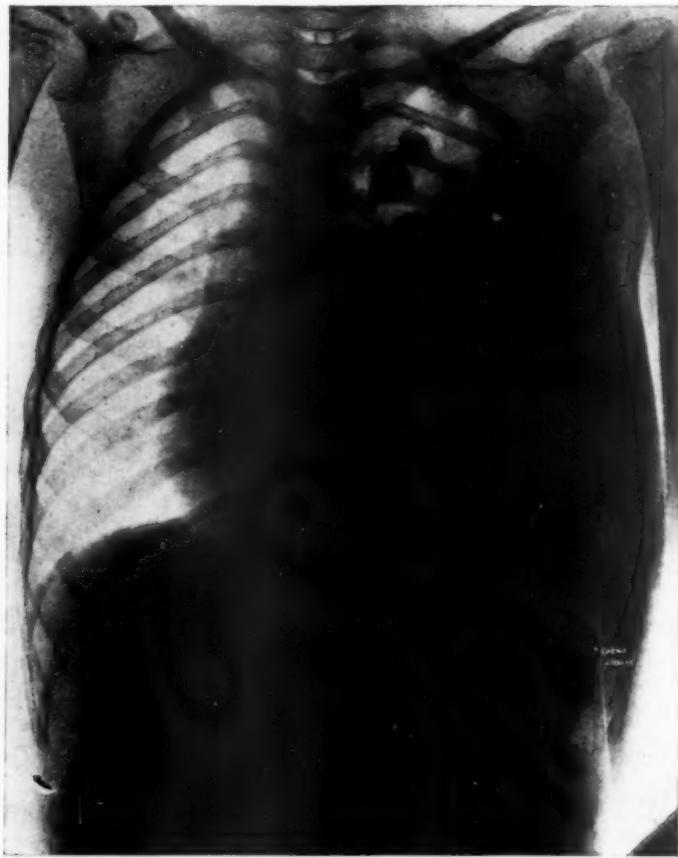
Radiograph, Case III, before operation.
